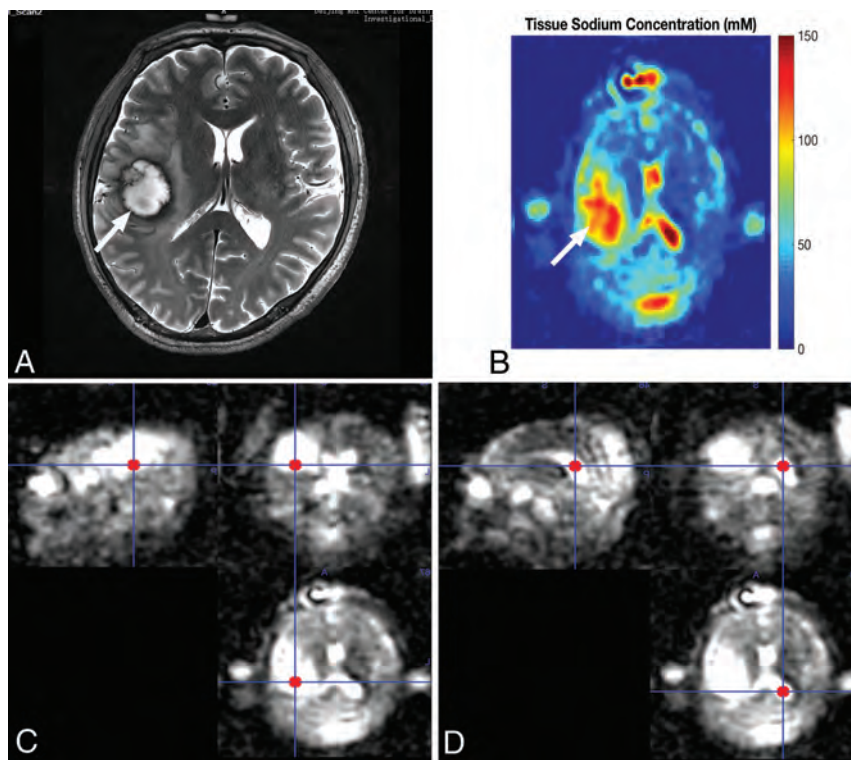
Proton and sodium MR imaging of tumor 1 at 7T. A, Axial T2-weighted image shows brain metastasis of rectal cancer at the right frontal-parietal lobe. B, The reconstructed sodium image. C and D, The ROI of the tumor and CSF in MRIcron software with the quantitative result.
